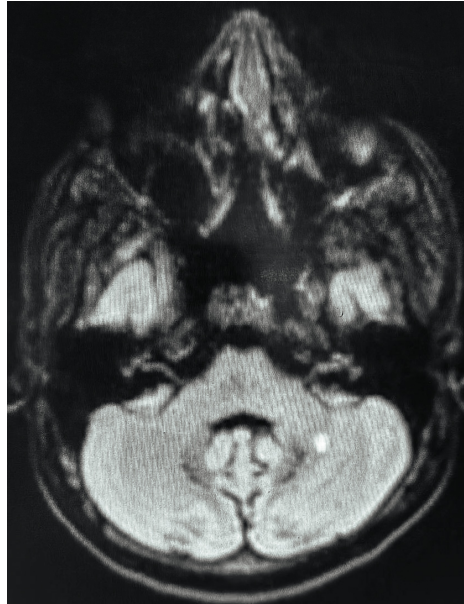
Diffusion-weighted imaging (DWI) showed marked focal hyper-intensity in the left cerebellum suggestive of an acute ischemic stroke.
